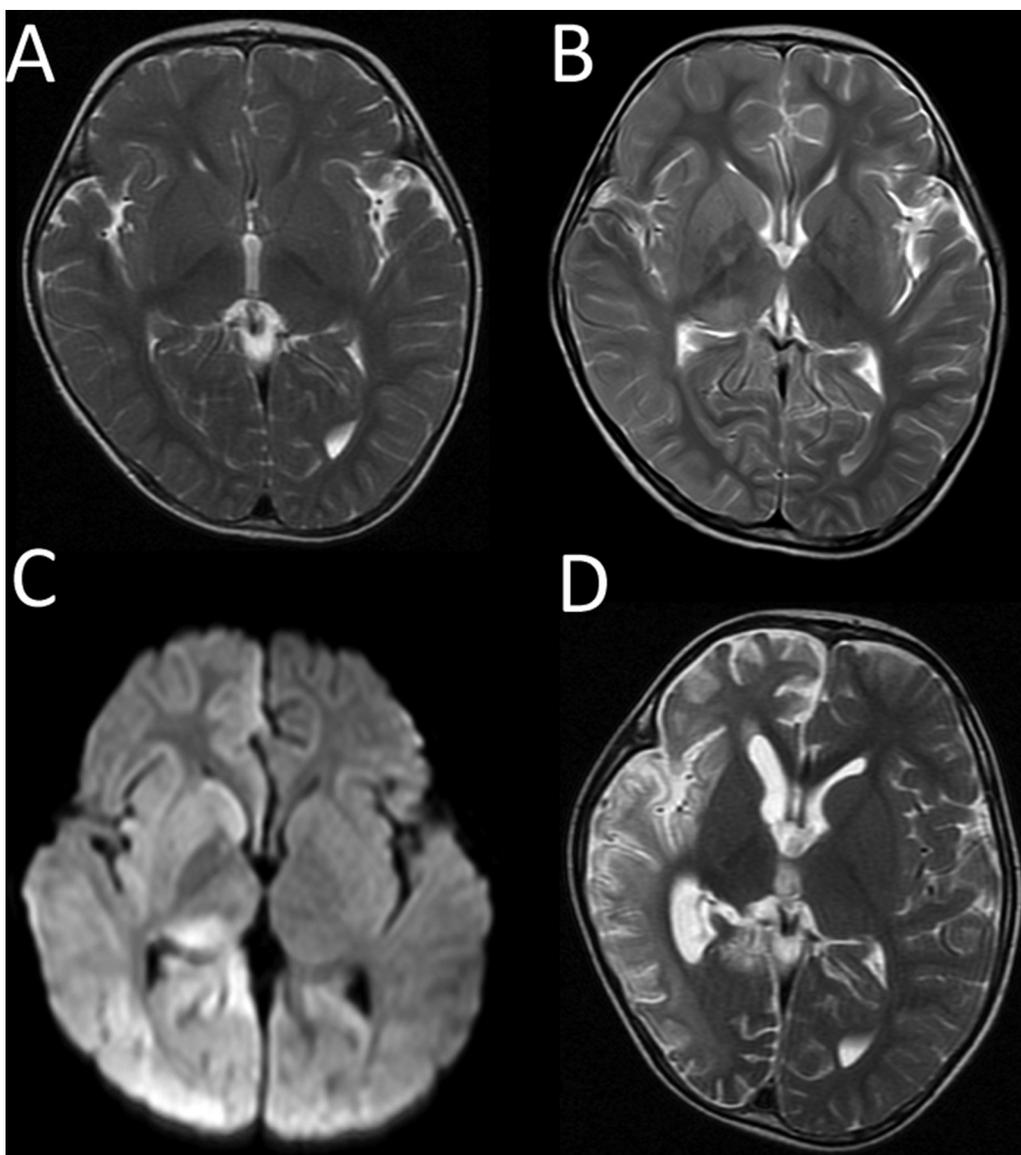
Normal MRI T2WI (A) (from Patient 8) after the first episode of SE 16 months prior to presentation. T2WI (B) and DWI (C) of the acute-phase MRI demonstrating restricted diffusion of the whole right cortex, basal ganglia, and thalamus. (D) T2WI obtained approximately two months later showing right-sided cerebral atrophy. DWI, diffusion-weighted image; MRI, magnetic resonance imaging; T2WI, T2-weighted image.
